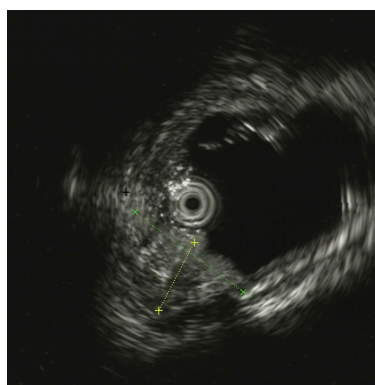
Endoscopic ultrasound examinations. Endoscopic ultrasound indicated that the lesion originated from the mucosal layer and partially involved the submucosal layer.
